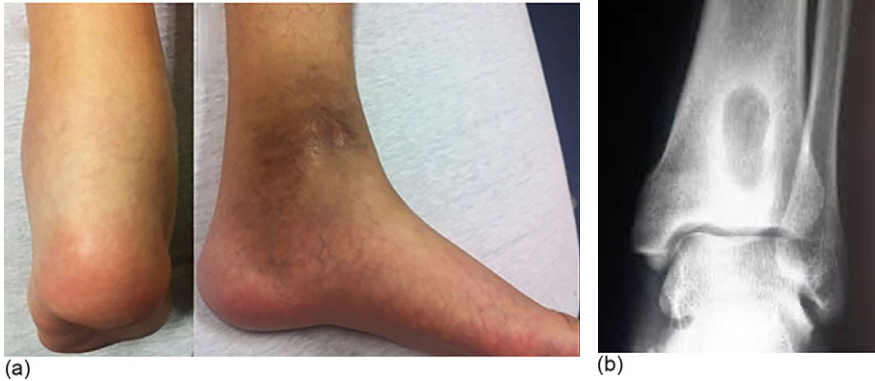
(a) Clinical photograph and (b) anteroposterior (AP) radiograph left ankle
